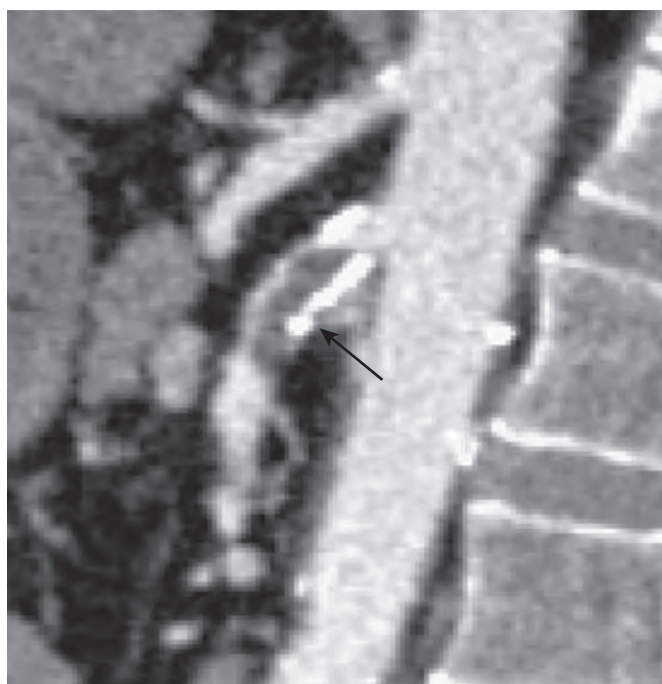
SMA thrombosis. Sagittal volume-rendered CT image demonstrates thrombus (arrow) formation at the origin of the SMA in a region of calcified atherosclerotic plaque.
